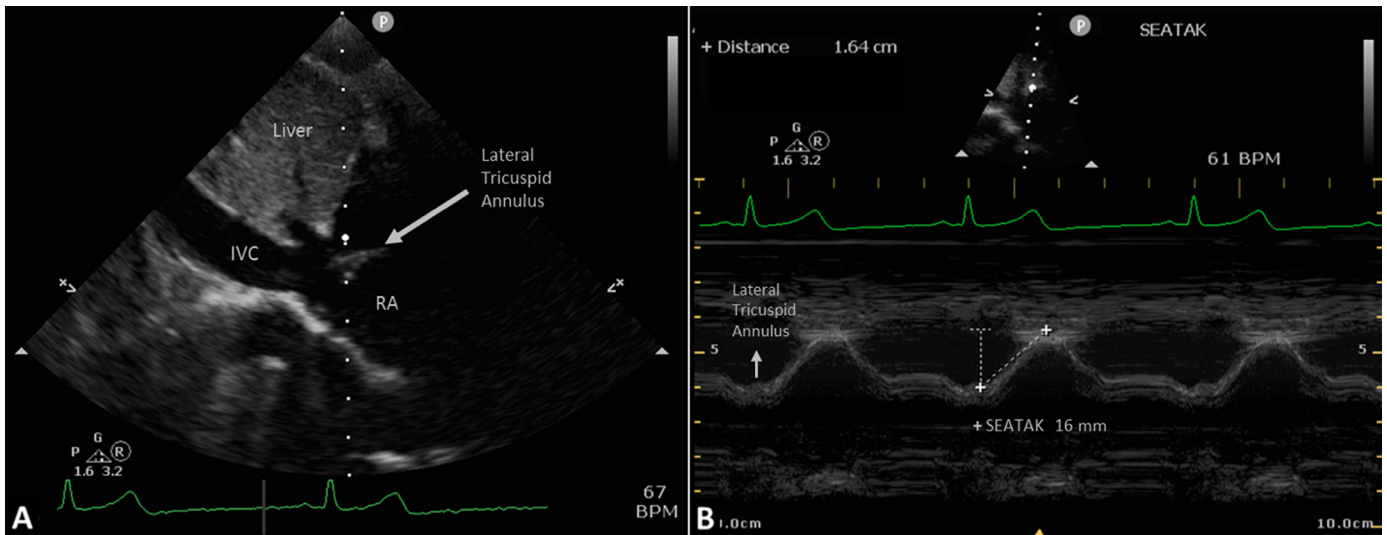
Subcostal echocardiographic assessment of tricuspid annulus kick by transthoracic echocardiography. (A) Two-dimensional image of subcostal window, inferior vena cava view describing the image acquisition before M-mode imaging of subcostal echocardiographic assessment of tricuspid annulus kick; the M-mode line (white dotted line) is placed through the lateral tricuspid annulus (arrow); then, M-mode imaging can be recorded. (B) M-mode image of the subcostal echocardiographic assessment of tricuspid annulus kick measurement (16 mm). The lateral tricuspid annulus (arrow) is depicted across several cardiac cycles. The subcostal echocardiographic assessment of tricuspid annulus kick is measured as the vertical excursion of the lateral tricuspid annulus from end-diastole to end-systole. IVC, inferior vena cava; RA, right atrium; SEATAK, subcostal echocardiographic assessment of tricuspid annulus kick.
